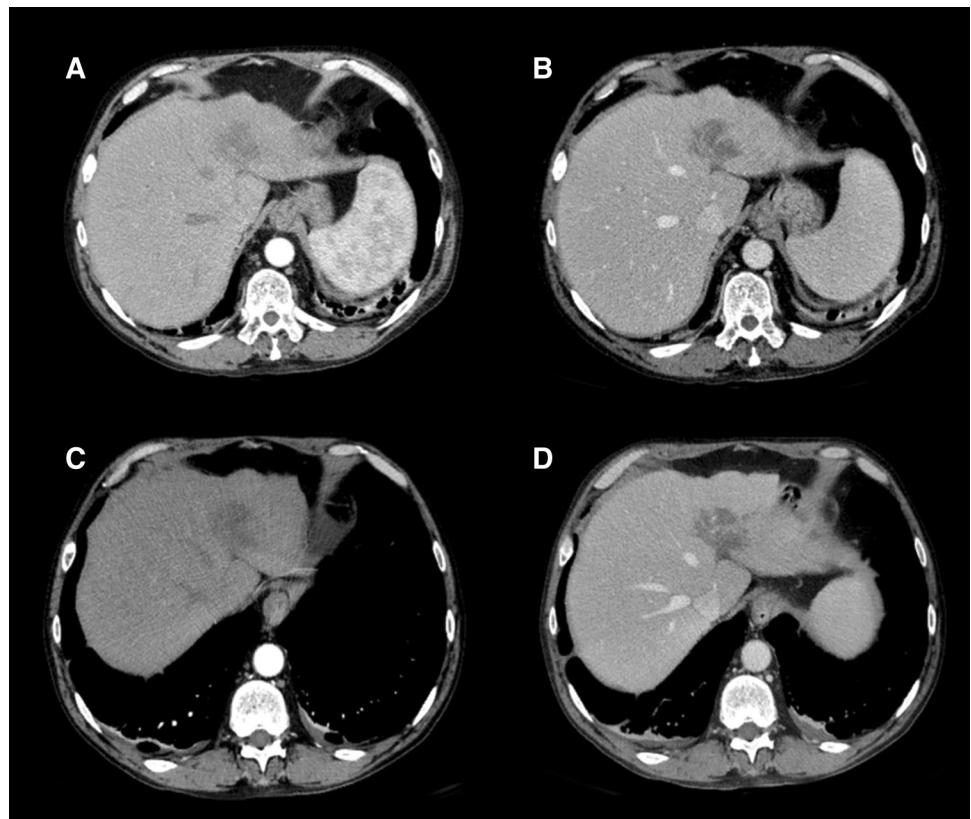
CT scan after intravenous injection of iodine contrast media acquired in portal-venous phase of a 62-years old female patient with diagnosis of Hodgkin Lymphoma and secondary liver involvement.
